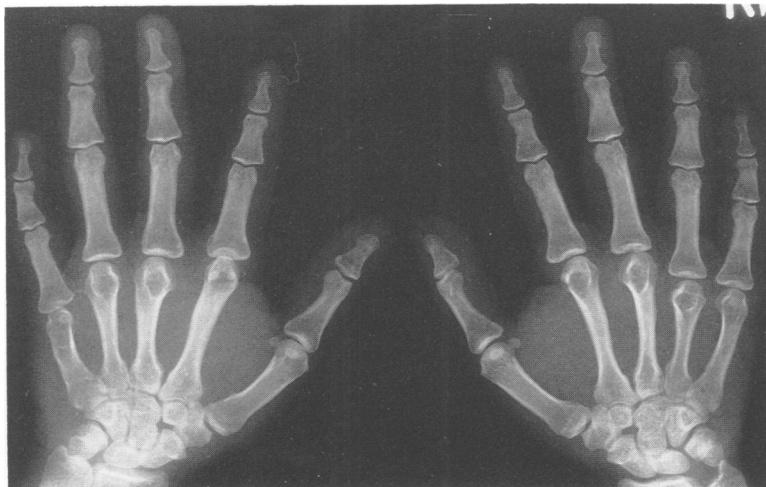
Hand radiographs without cone shaped epiphyses.
